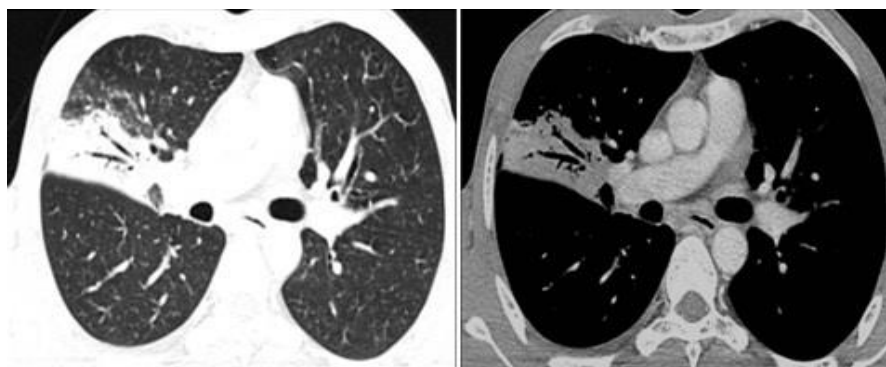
HIV-positive patient with bacterial pneumonia. Axial HRCT (a) lung window (b) mediastinal window. Area of consolidation seen involving posterior segment of right upper lobe with adjacent areas of ground glass opacity
